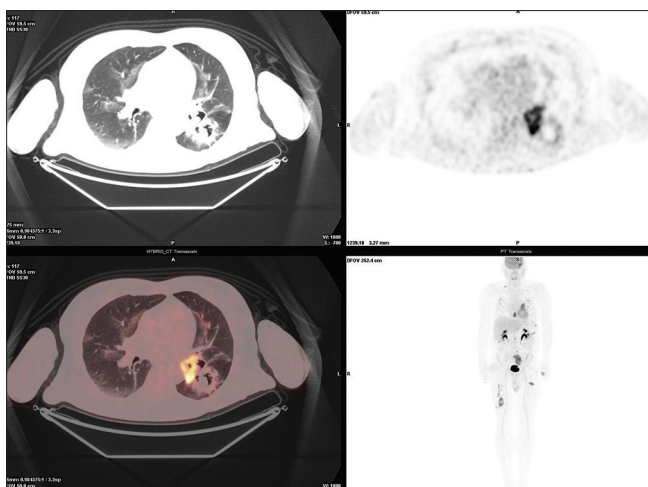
Transaxial positron emission tomography–computed tomography slice showing area of increased ^{18}F -fluorodeoxyglucose uptake of the left lower lobe lung mass without mediastinal adenopathy
